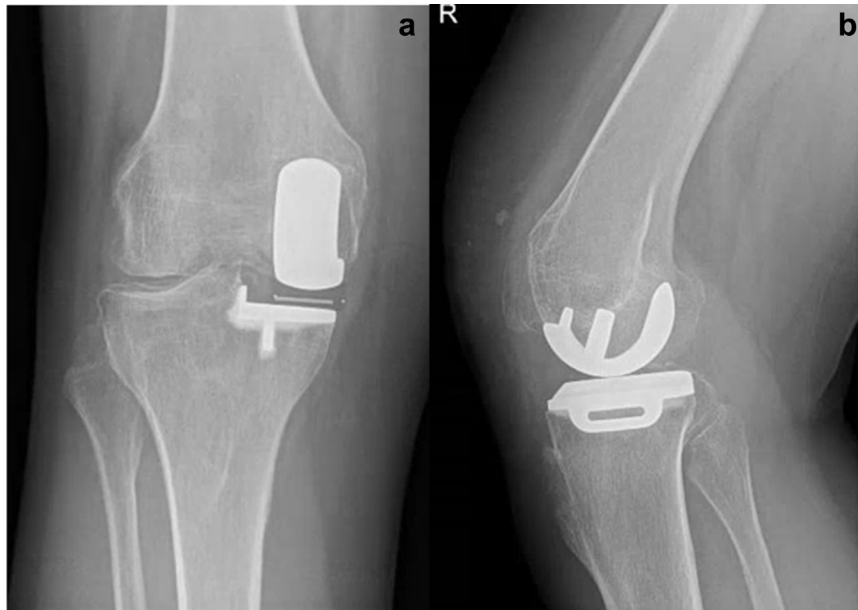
Anteroposterior (a) and lateral (b) radiographs 3 months postoperative.
